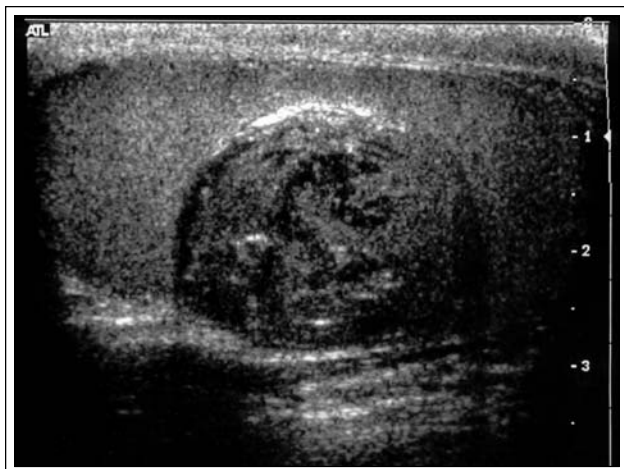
Scrotal ultrasound depicting sagittal view of right testis demonstrating a hypoechoic intratesticular mass with a well-defined, hyperechoic cystic wall.
